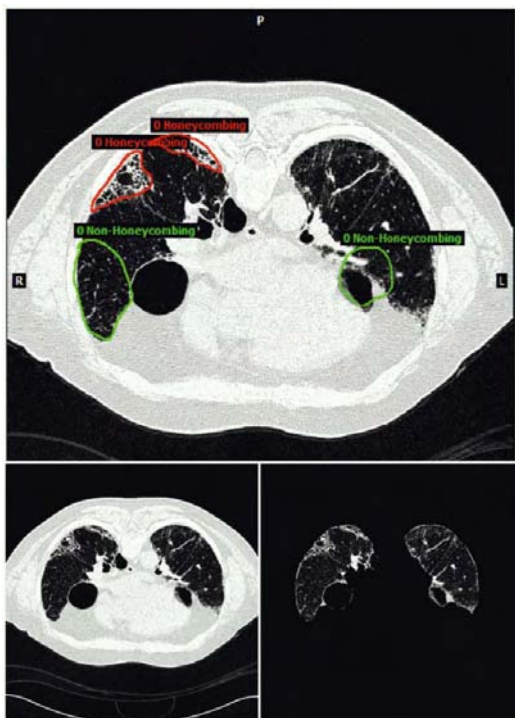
Top: an image with marked and labelled regions by a radiologist showing disease patterns; bottom left: original HRCT image, bottom right: segmented lungs.
